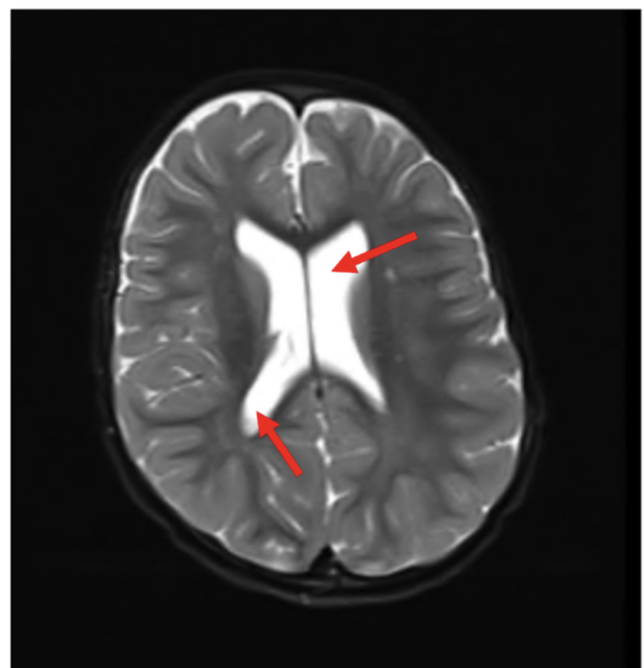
Brain MRI showing mild prominence of the cerebral ventricles and cortical sulci
